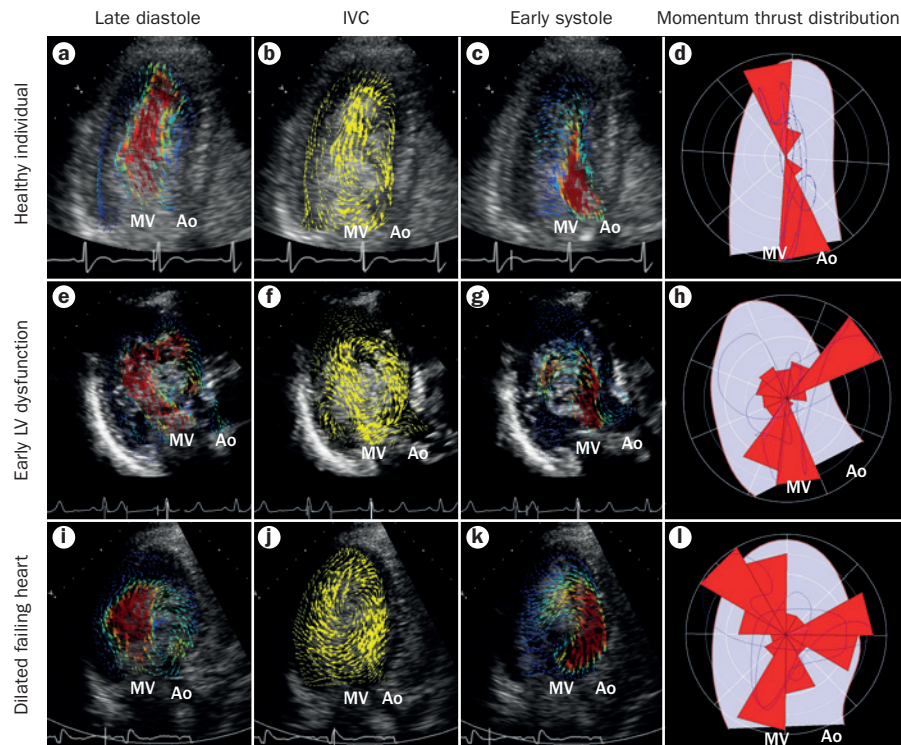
Echocardiographic recordings of intraventricular flow. a–d | A healthy individual. e–h | A patient with subclinical diastolic dysfunction. i–l | A patient with dilated cardiomyopathy. Velocity vectors are shown at late diastole (parts a, e, and i), during IVC (parts b, f, and j), and in early systole (parts c, g, and k). Colours in late diastole and early systole represent kinetic energy (from blue to red), arrow lengths are amplified during low-velocity IVC. The polar histogram of the frequency and intensity of intraventricular forces is shown in parts d, h, and l. Momentum thrust is the integrated result of IVPG, and is composed of gradients of kinetic energy and flow acceleration representing the force acting on the entire mass of fluid. The observed base–apex orientation of intraventricular forces perfectly matches with LV geometry, with a highly curved apex and rectilinear side walls, and ensures correct interaction between blood flow and myocardial tissue. Normal blood flow develops along the longitudinal axis in association with the filling–emptying mechanism. The longitudinal orientation is lost in the presence of early LV dysfunction, and the initiation of transversal forces might stimulate LV adaptation. At later stages of LV failure, the streamlines become rounded and the base–apex function is replaced by disorganized dynamic actions. Abbreviations: Ao, aorta; IVC, isovolumic contraction; IVPG, intraventricular pressure gradients; LV, left ventricular; MV, mitral valve.
